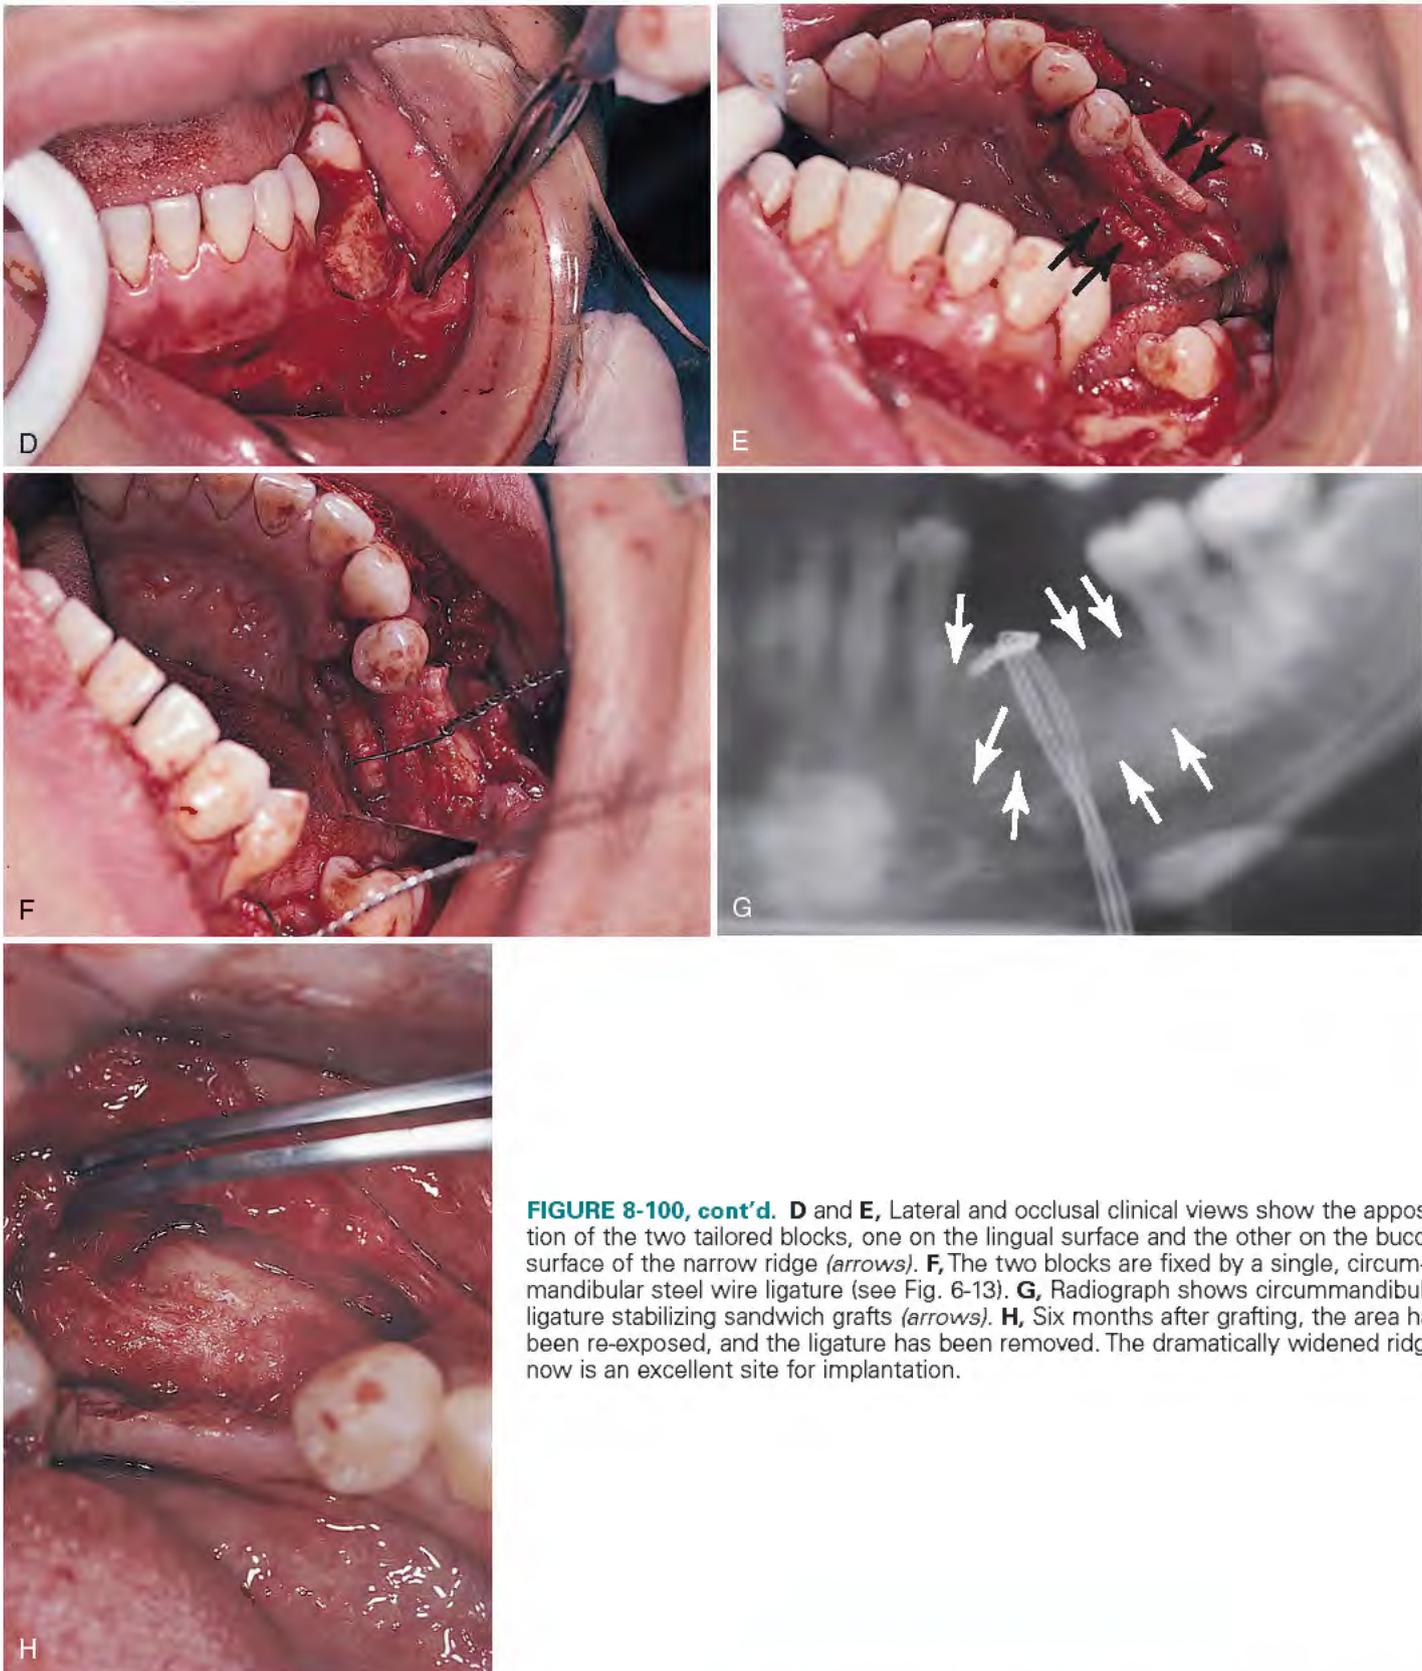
cont'd. D and E, Lateral and occlusal clinical views show the apposition of the two tailored blocks, one on the lingual surface and the other on the buccal surface of the narrow ridge (*arrows*). F, The two blocks are fixed by a single, circummandibular steel wire ligature (see Fig. 6-13). G, Radiograph shows circummandibular ligature stabilizing sandwich grafts (*arrows*). H, Six months after grafting, the area has been re-exposed, and the ligature has been removed. The dramatically widened ridge now is an excellent site for implantation.
